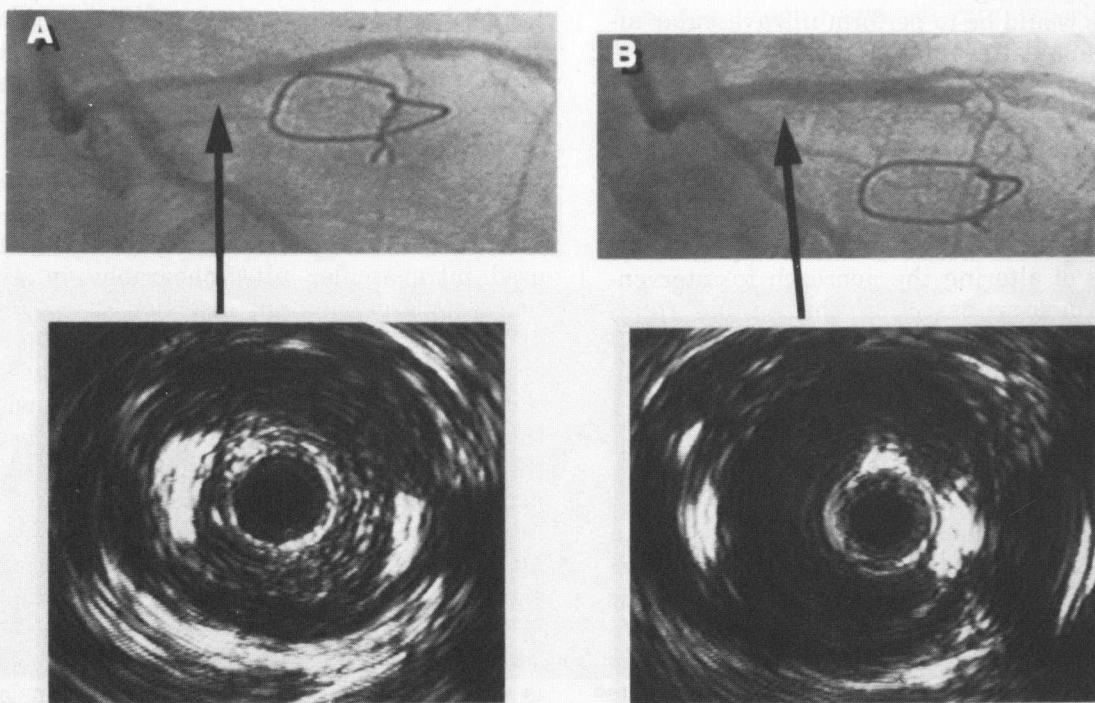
Directional atherectomy was performed in this patient who had previous balloon angioplasty with restenosis. (A) The proximal left anterior descending stenosis is shown before treatment. There is a near occlusive atherosclerotic plaque with two areas of calcification at 3 o'clock and 10 o'clock. (B) Following the atherectomy, the angiographic result was excellent. By intravascular ultrasonography, significant plaque removal was confirmed. There is removal of plaque up to the point of the calcification but not beyond. Attempts at further atherectomy would most likely lead to deflection of the cutter toward the normal vessel wall with removal of media and adventitia.
